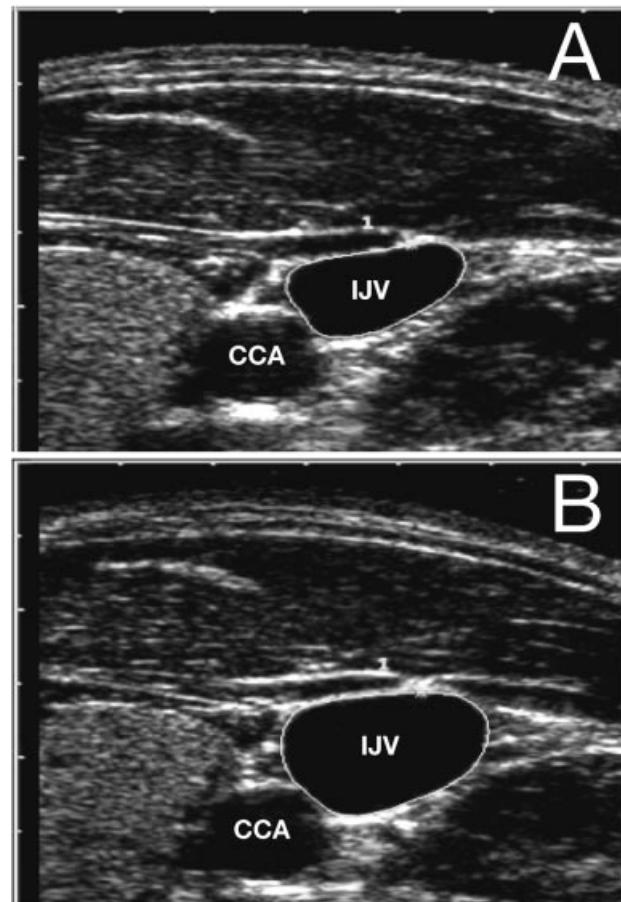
Cross-sectional B-mode ultrasound scan. (A) Right IJV. CSA of a subject in the supine position; area 43.9 mm². (B) CSA in the same subject during 10° head-down tilt; area 73.2 mm². CCA = common carotid artery.
